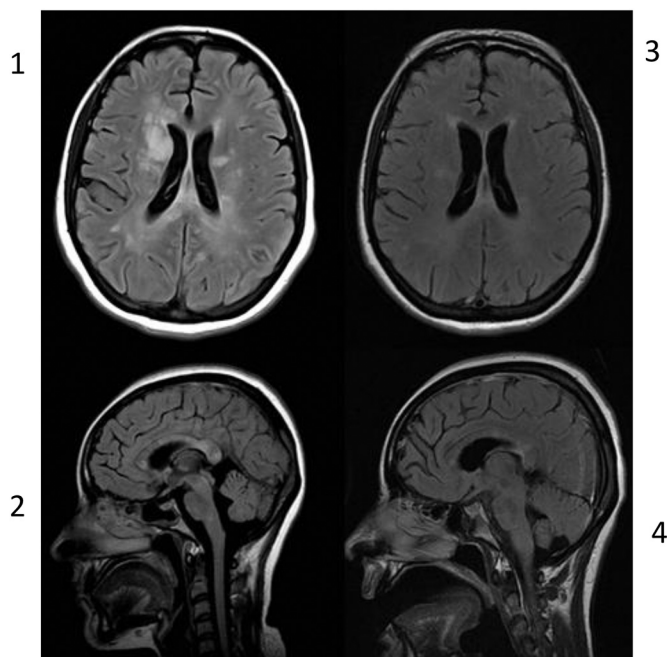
MRI FLAIR sequence. Part 1 and 2 Pretreatment images shows hyperintense lesions with predominantly pericallosal involvement in the subependymal striations and the snowball lesions. Part 3 and 4 shows IgIV post treatment changes with almost complete disappearance of the previous lesions.
